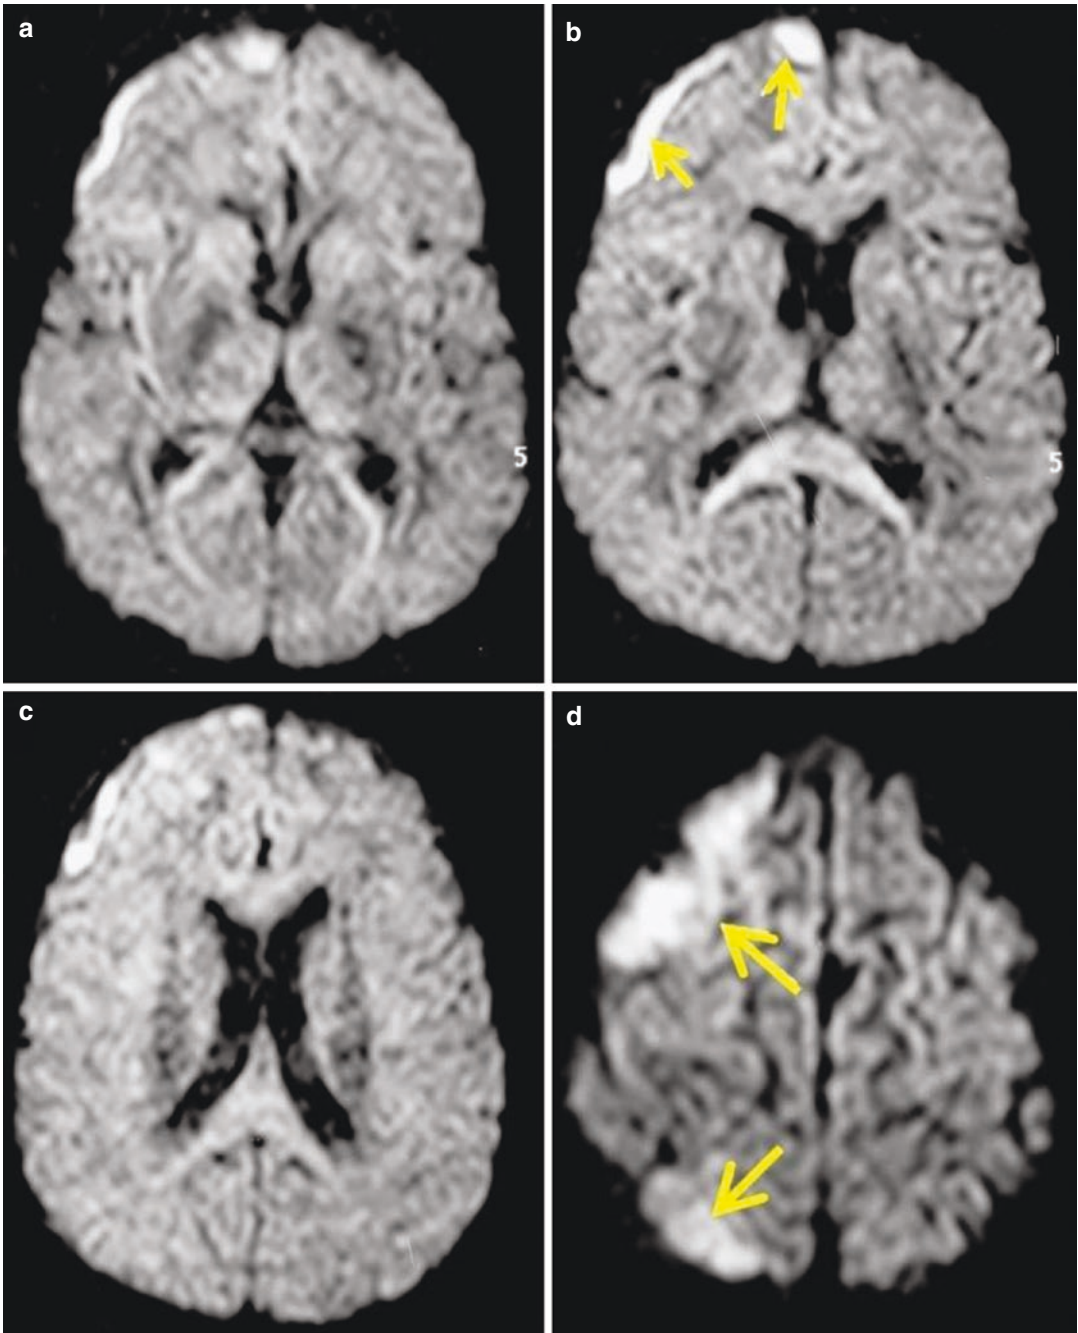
Case 1. Axial cranial enhanced CT scan showing multiple subdural empyemas in the right side (a–d). (Reproduced from Akhaddar A. (2017) Cranial Subdural
